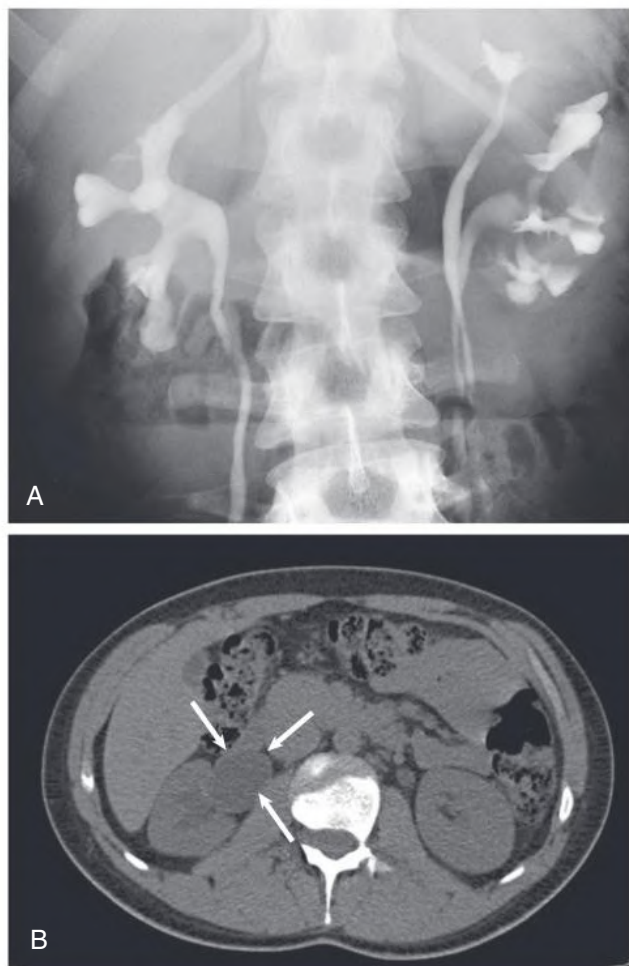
Duplex Kidney. (A) Intravenous urogram shows a duplex left kidney. The lower pole is scarred and shows evidence of reflux damage. The two ureters enter the bladder separately, with the lower pole ureter in the abnormal location. The right kidney also shows features of reflux, with clubbing of the calyces and some scarring. (B) Computed tomography scan shows an isolated right-sided megaureter (arrows).
